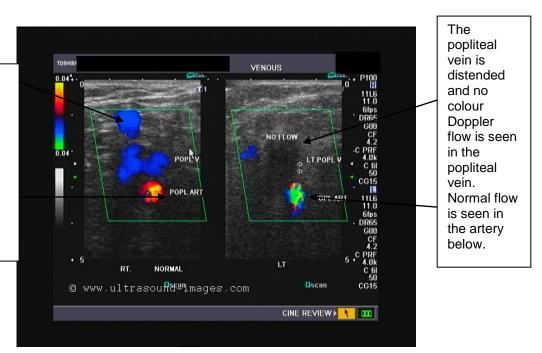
A colour Doppler ultrasound, transverse plane image of the popliteal vessels. A DVT is visualsised in the left popliteal vein with absent colour flow (see the right side of the above figure 1.8). The right popliteal vessels (on the left side of the above figure) show normal colour Doppler flow in both the popliteal vein and artery. (Ultrasound Image Gallery, 2012)
